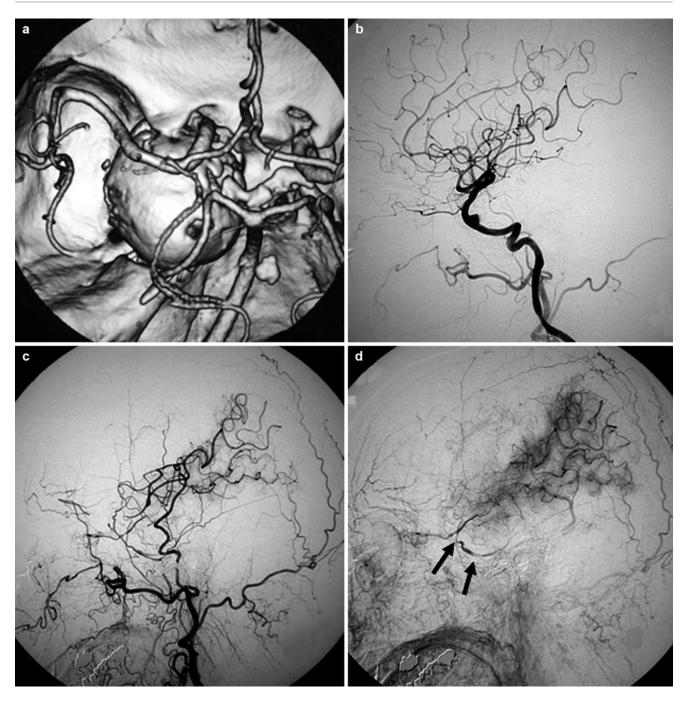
Case 3. (a) Preoperative 3D-CT angiogram showing a giant aneurysm in the left cavernous sinus. (b) Preoperative left carotid angiogram demonstrating a partially thrombosed giant cavernous sinus
